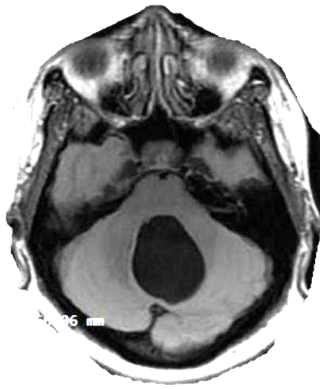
FLAIR MRI Scan showing a nulling of the lesion signal in keeping with CSF
